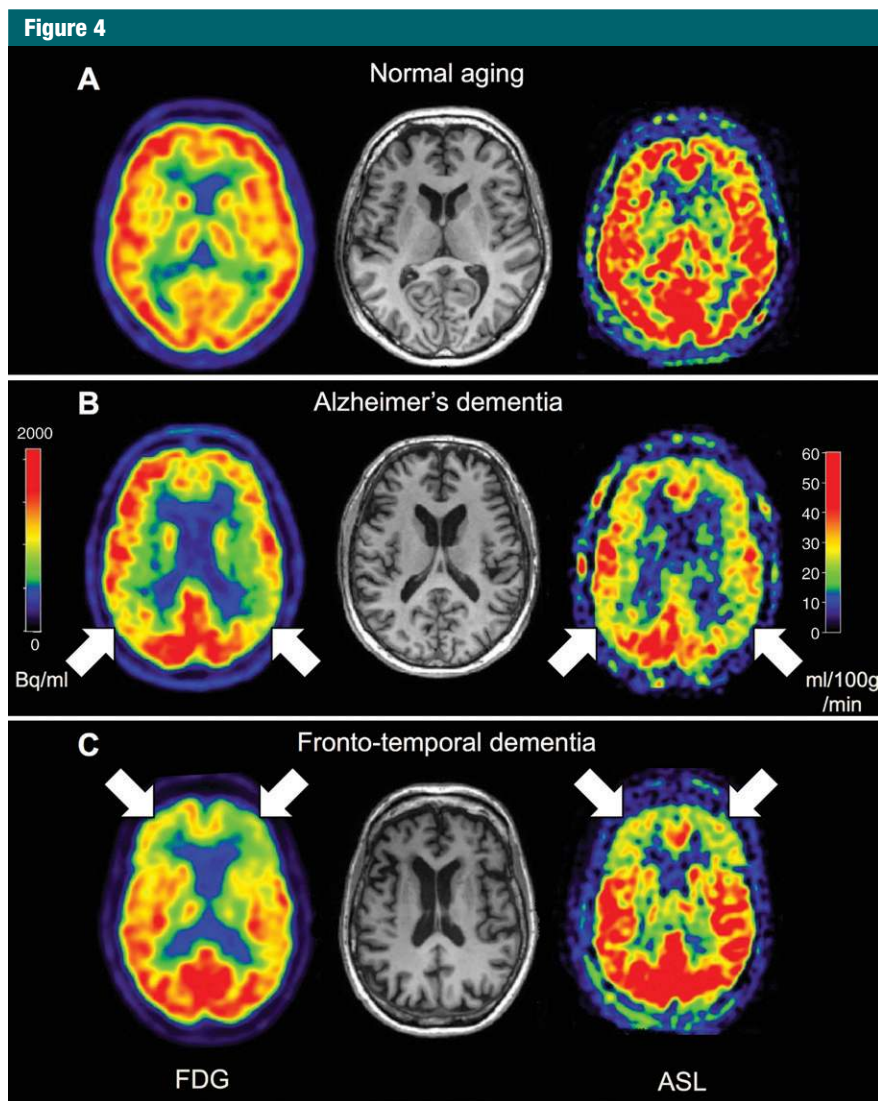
Examples of dementia. Transverse FDG and ASL images of, *A*, a healthy individual (male; age, 57 years; Mini-Mental State Examination [MMSE] score, 30), *B*, patient with AD (male; age, 52 years; MMSE score, 19), and, *C*, patient with frontotemporal lobar dementia (female; age, 53 years; MMSE score, 26). Functional images show predominant prefrontal abnormalities in FTD and parietal abnormalities in AD. Red color reflects normal metabolism and perfusion.
